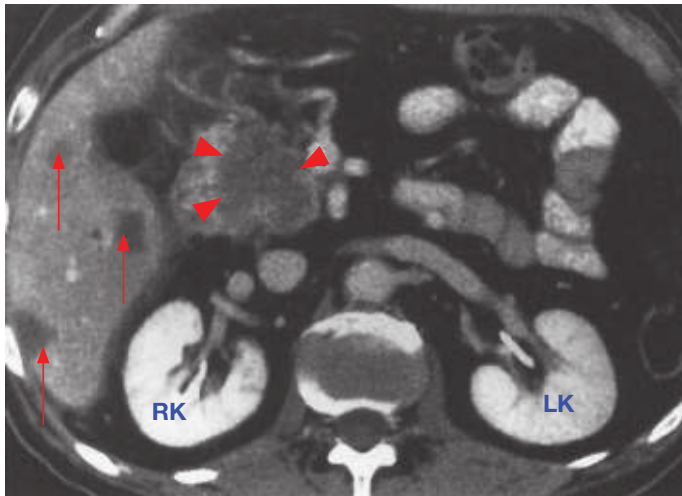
Pancreatic adenocarcinoma. Transaxial contrast-enhanced CT shows a mass in the head of the pancreas (*arrowheads*) and multiple liver metastases (*arrows*). RK, right kidney; LK, left kidney. (Reproduced with permission from Chen MY et al. *Basic Radiology*, 2nd ed. New York: McGraw-Hill, 2011, Fig. 11-71.)
